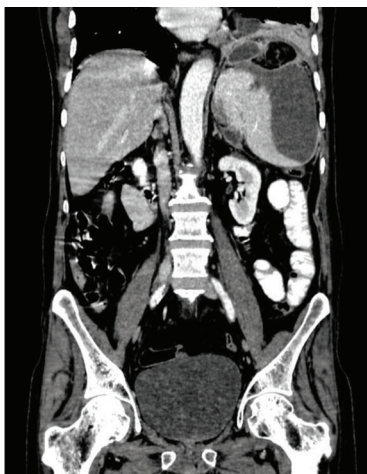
Contrast Coronal CT section shows subcapsular splenic collection.
